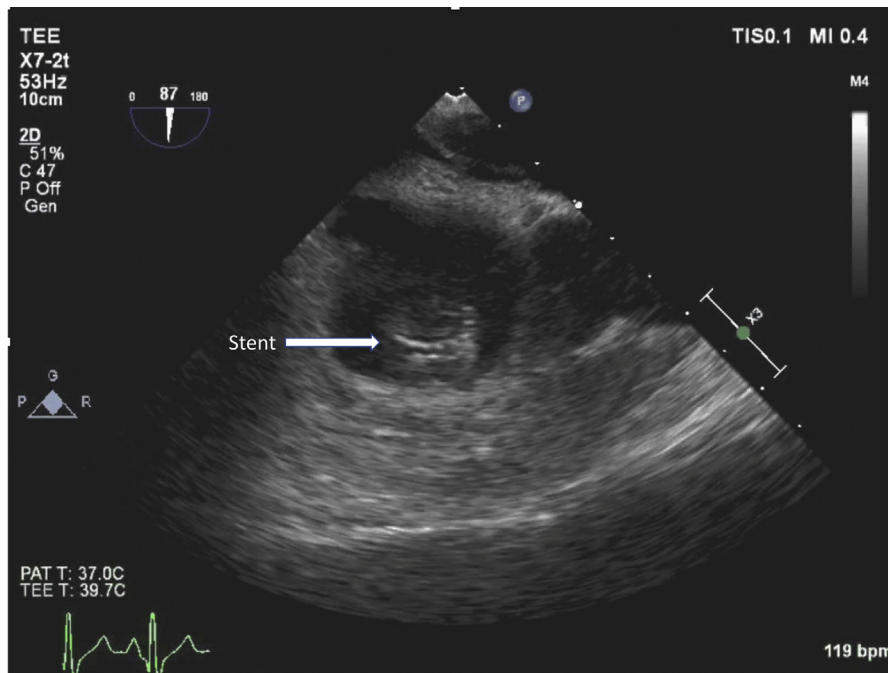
Transesophageal echocardiography (TEE) confirming stent location (arrow) across tricuspid valve.
